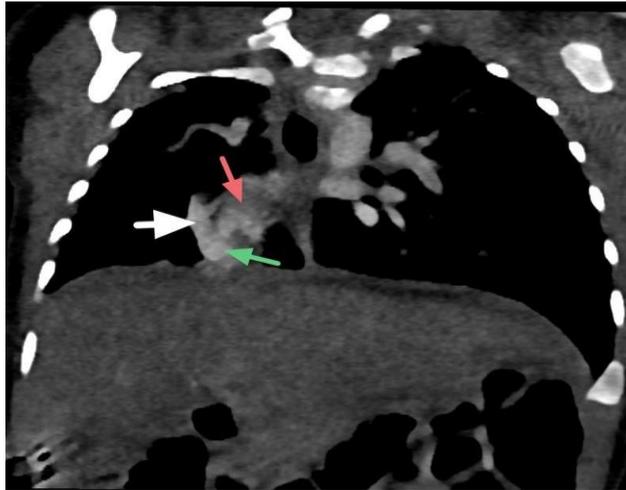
CT cardiac coronal reformatted view showing middle lobe pulmonary vein (white arrow) draining into inferior vena cava (green arrow).
